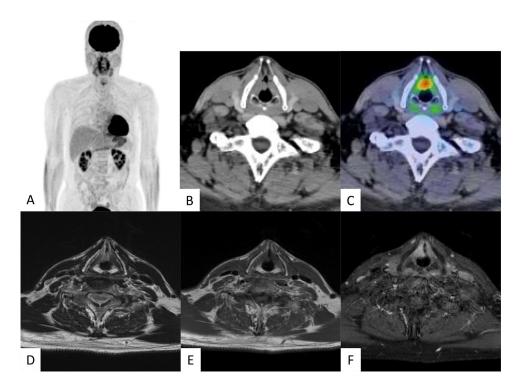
Diagnostic images of a 62-year-old male with T3N0M0 stage III right glottic cancer (case 1). (A) Maximum intensity projection positron emission tomography (PET); (B, C) axial computed tomography and fused positron emission tomography/computed tomography images showing intense fluorodeoxyglucose uptake in the right glottic tumor (maximum standardized uptake value, 5.9); (D) T2-weighted image; (E) T1-weighted image; (F) gadolinium-enhanced fat-suppressed T1-weighted images showing involvement of the paraglottic space.
